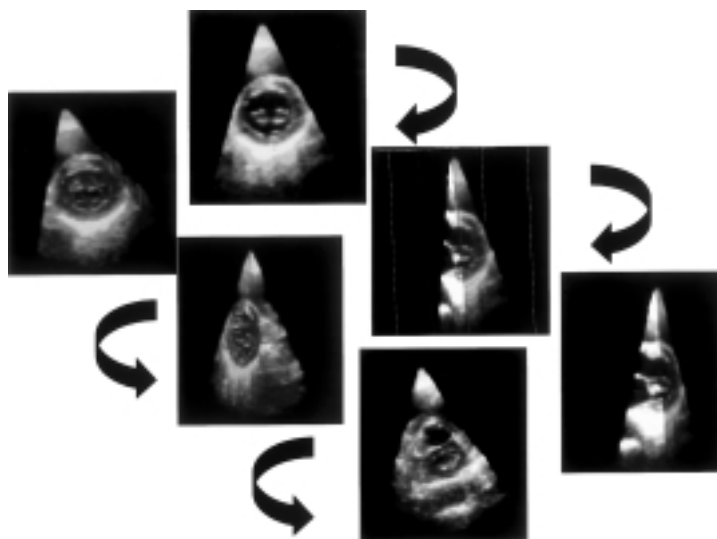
Live three-dimensional images of the mitral valve (short-axis parasternal view) showing how the pyramidal volume can be rapidly rotated (arrows) allowing a complete three-dimensional reconstruction of the anatomical plane.
